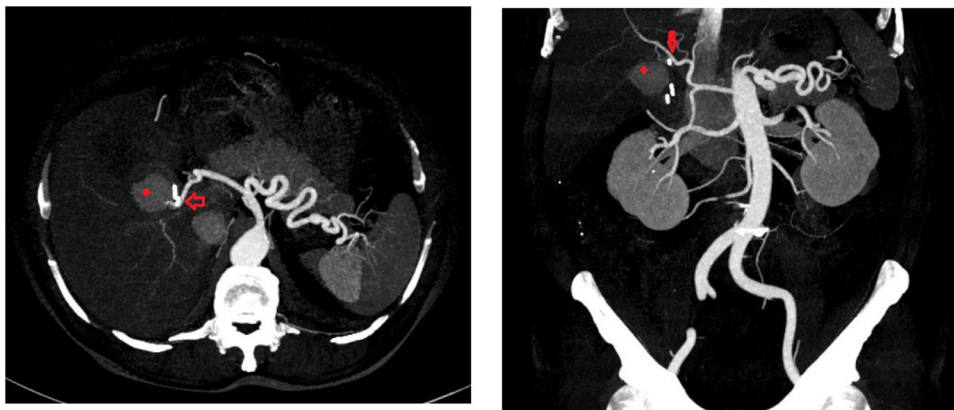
Axial and coronal reformatted contrast enhanced computed tomography (CECT) maximum intensity projection images showing the pseudoaneurysm (red pointer) arising from the right hepatic artery (red arrow).
